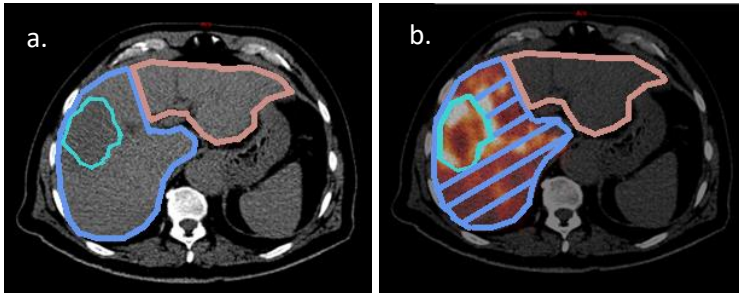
Segmentation of non-tumoral liver (NTL) on ^{90}Y PET. (a) CT and (b) ^{90}Y PET/CT on the axial plane. After the right lobe (blue), left lobe (tan) and tumor(s) (green) are segmented on the CT (a) and propagated to the PET/CT (b), the NTL is obtained by excluding the tumor volume from the target liver (blue lines).
